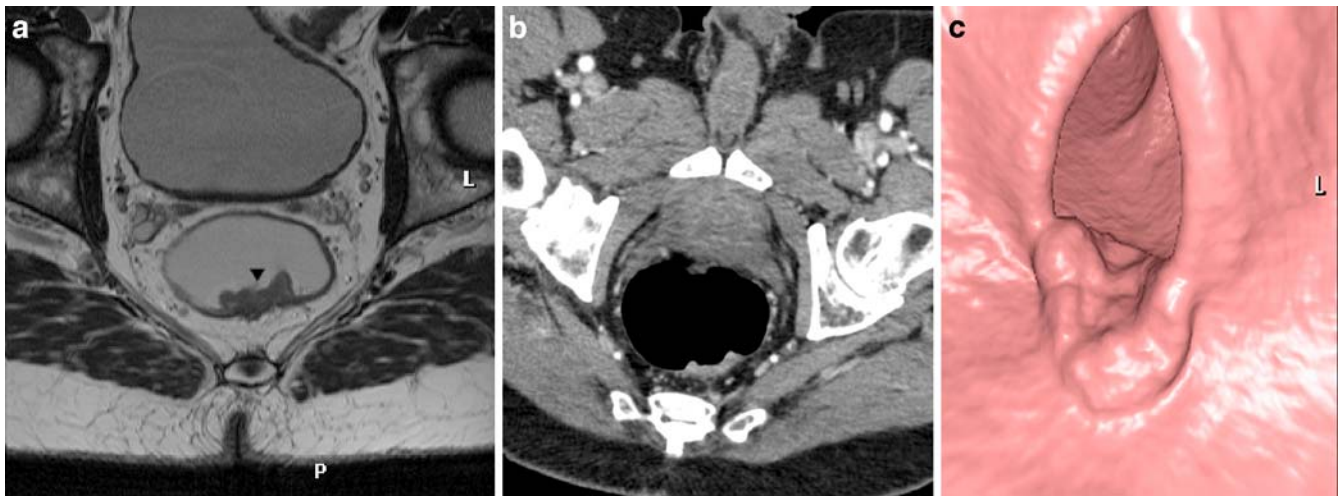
a Paraxial T2-weighted FSE (TSE) sequence. T1/2 rectal cancer. The relatively hyperintense intraluminal tumor (arrowhead) is confined to the rectal wall. Tumor invasion of the mesorectum is
